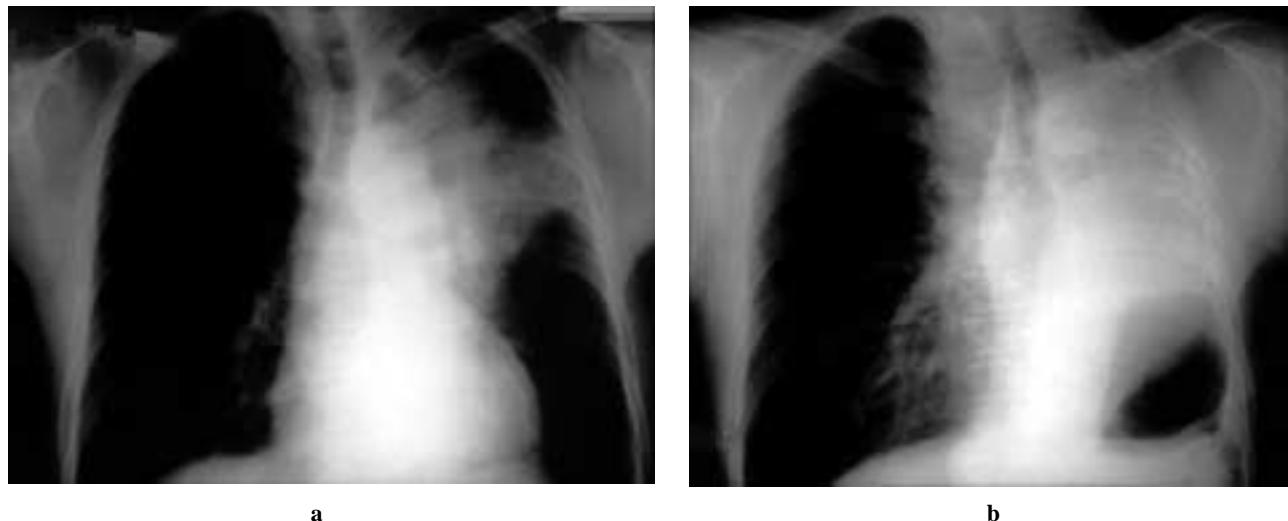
Case 3. Chest X-rays (a: preoperative view, b: postoperative view) for a patient with huge left hilar mass who underwent left pneumonectomy with intra-pericardial dissection for the left main pulmonary artery (55-year-old-man with squamous cell carcinoma. p-T4N1M0).
